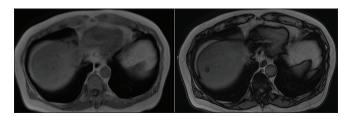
Axial in- and opposed-phase images of initial magnetic resonance imaging liver
